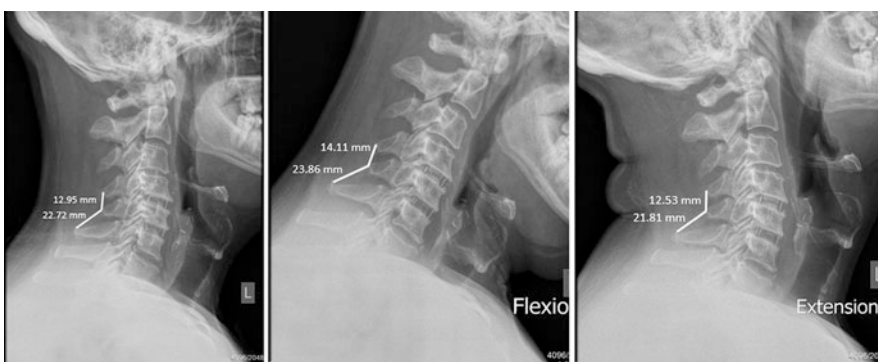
Lateral X-ray views of the cervical spine showing method of measuring interspinous process distance
